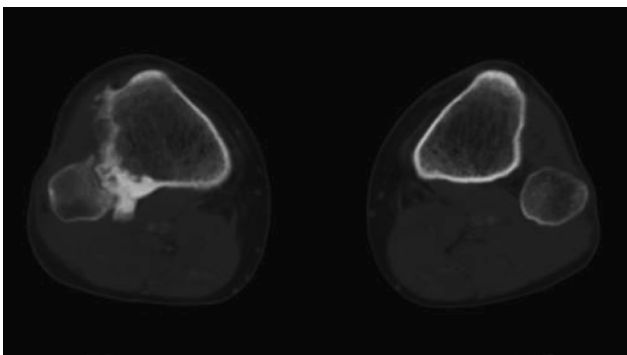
CT scan of the knee shows a cortical lesion of the proximal tibia which produces bone and violates the tibiofibular articulation.
